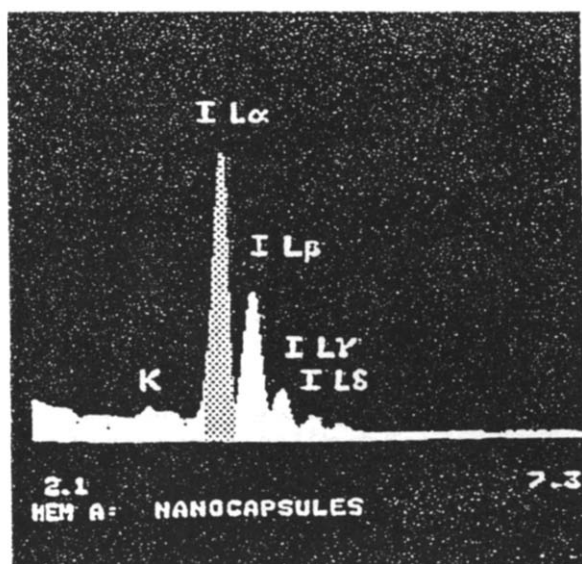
X-ray analysis of a Lipiodol nanocapsule indicating the different L-lines (α , β , γ , δ) of iodine.
